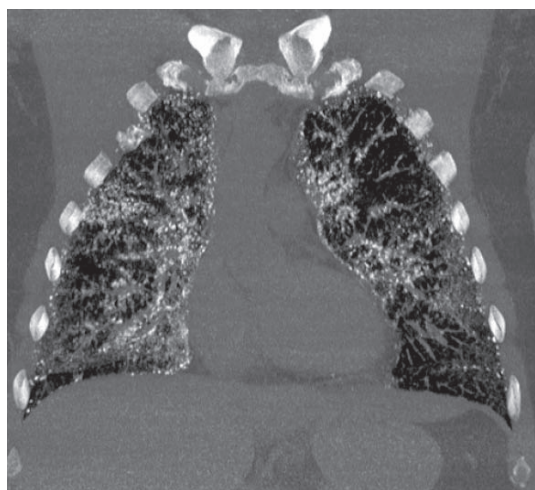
HRCT sections showing ground glass attenuation with inter and intralobular septal thickening with multiple calcified nodules predominantly in lower lobes and in sub-pleural location.
